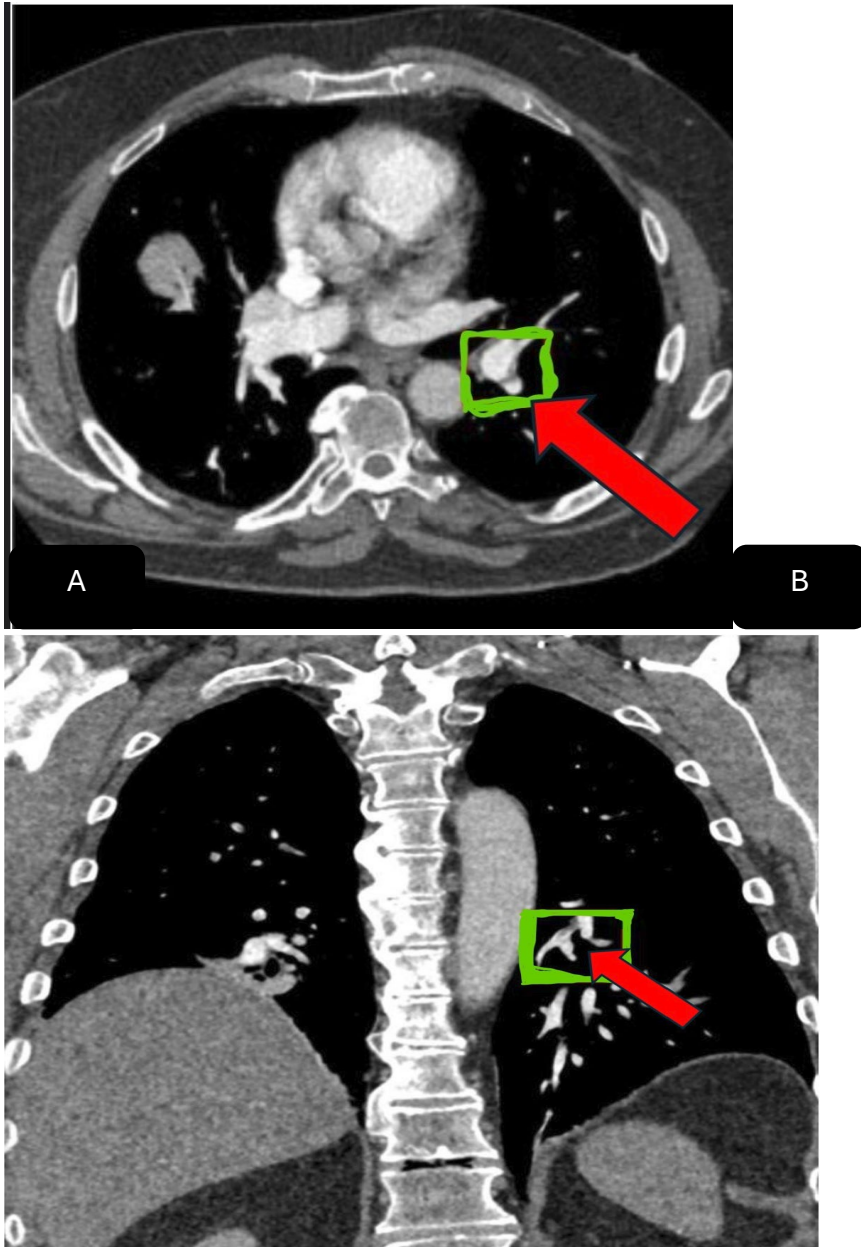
A: Axial view of a CT pulmonary angiogram with red arrow demonstrated filling defect in the left main pulmonary embolism.
